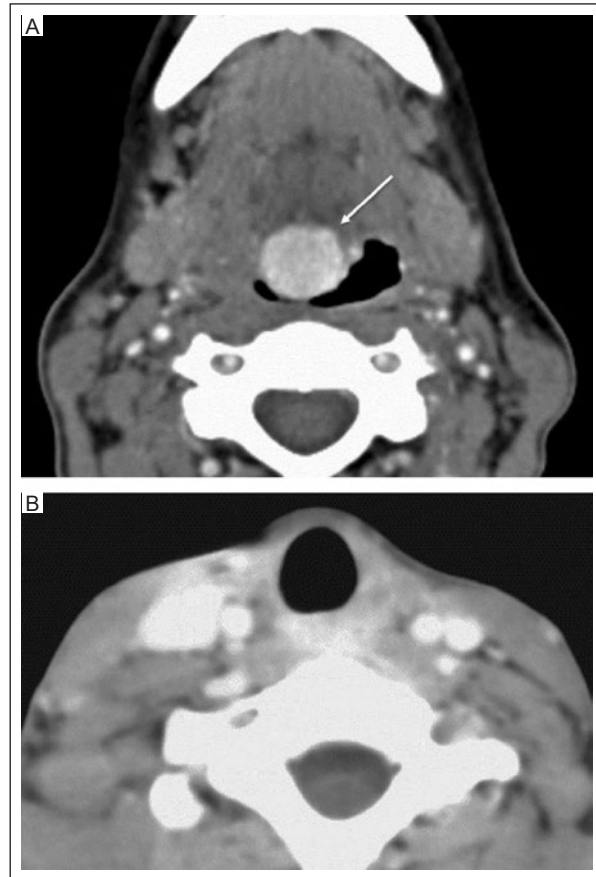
Ectopic thyroid. A: axial contrast-enhanced CT of the neck at the level of tongue base, and B: at the level of thyroid bed shows a well-circumscribed rounded hyperattenuating lesion in the midline tongue base at the expected location of the foramen cecum consistent with ectopic thyroid tissue (arrow). Also, note no appreciable thyroid tissue in the thyroid bed.
